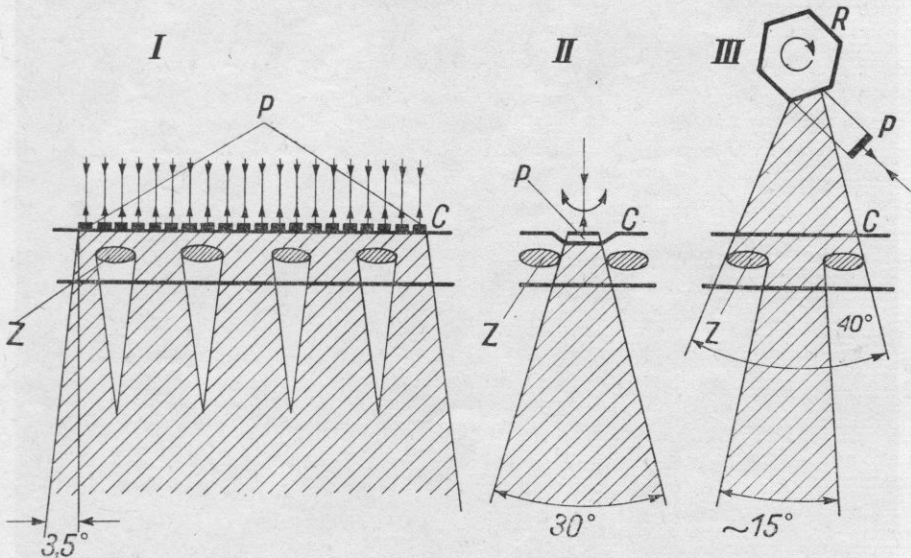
Various methods of ultrasonic visualization of the heart in real time: I - with a transducer array [1, 7], II - with one oscillating transducer [2, 4], III - with one revolving reflector (IPPT-PAN)
